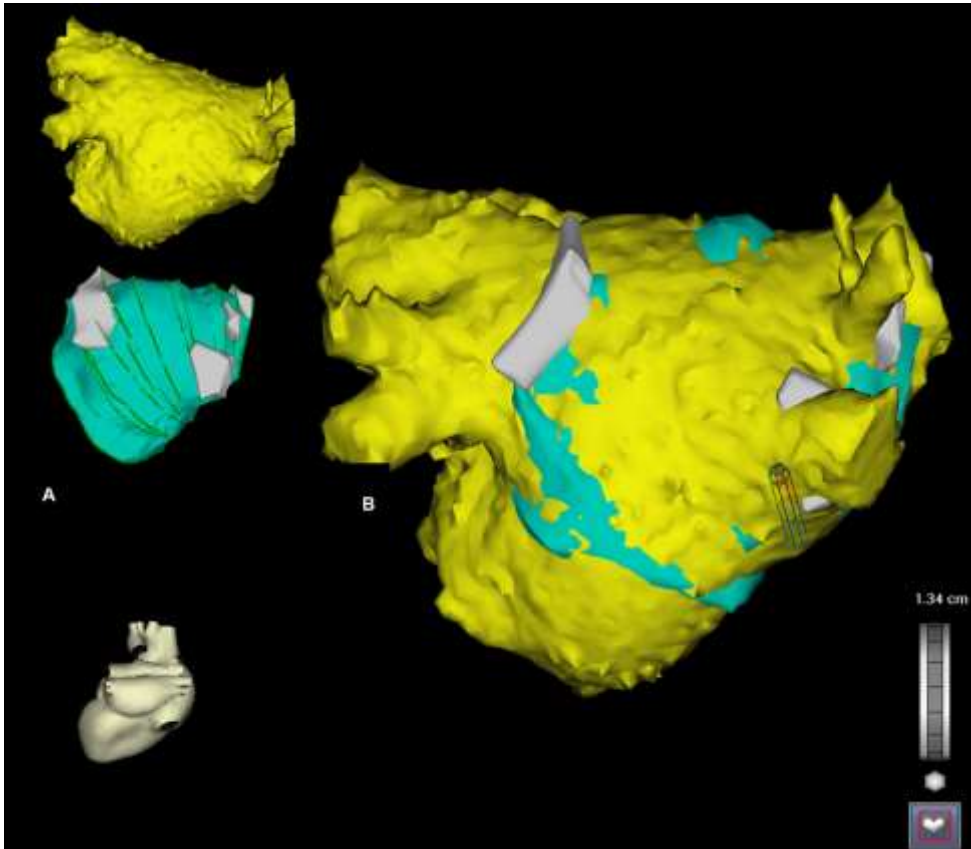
After three-dimensional (3D) mapping with intracardiac echocardiography, the 3D map and multi-slice computed tomography (MSCT) image are displayed next to each other (A). Then a manual registration process was performed. This resulted in the integration of the 3D map and the MSCT image in order to anatomically guide the ablation procedure (B).
